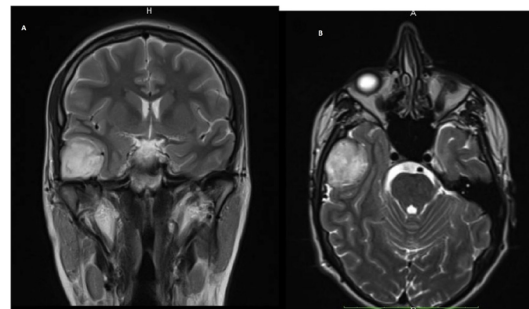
Preoperative MRI, axial (A) and coronal (B) planes.
